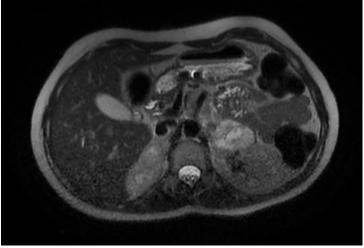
MRI showing the two adrenal glands tumors
